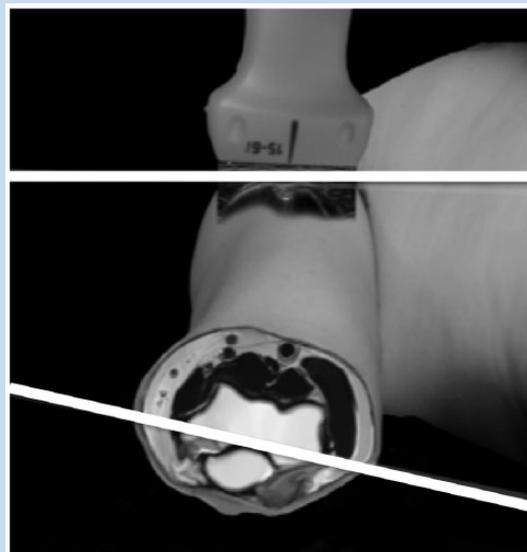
Humeral torsion. Humeral torsion was assessed by a sonographer who rotated the participant’s humerus until the apices of the tuberosities were oriented parallel to the plinth under ultrasound imaging. Once aligned, a second examiner recorded the relative rotation angle via a digital inclinometer.
